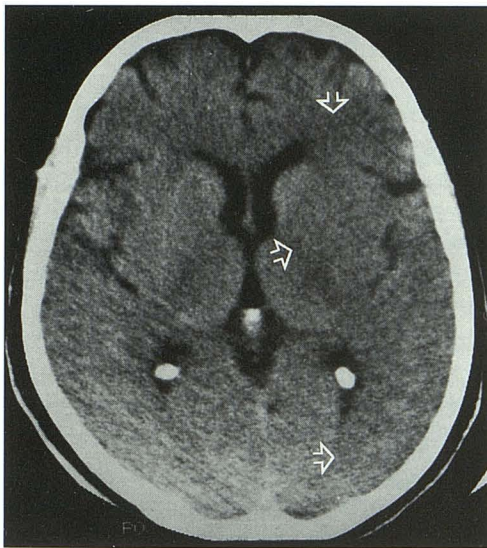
Noncontrast CT performed 113 minutes after sudden right-sided hemiparesis in a 62-year-old woman with angiographically proved MCA trunk occlusion shows extensive parenchymal hypodensity covering nearly 100% of the MCA territory.
